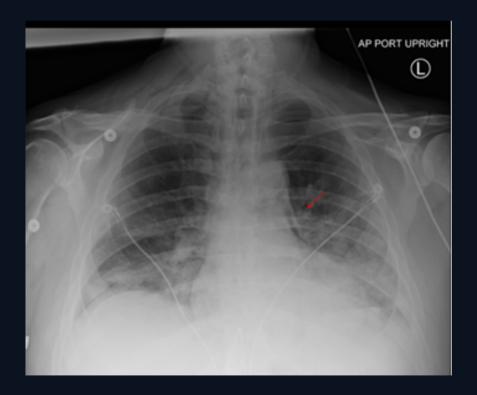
Chest radiograph two days later demonstrates bilateral basal and peripheral airspace opacification which has increased since the prior radiograph. There is a small rim of air at the AP window extending down the left heart border. Oblique strips of air in the lower neck represent subcutaneous emphysema.
